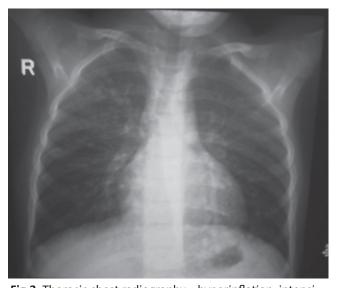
Thoracic chest radiography – hyperinflation, intensified pulmonary pattern, apical deformation and basal on the left, polymorphic, cystic deformations, S3 on the right, S5, S10 on the left. 7-year-old child with CF, chronic Ps. aeruginosa pulmonary infection, CFTR genotype delF508/
